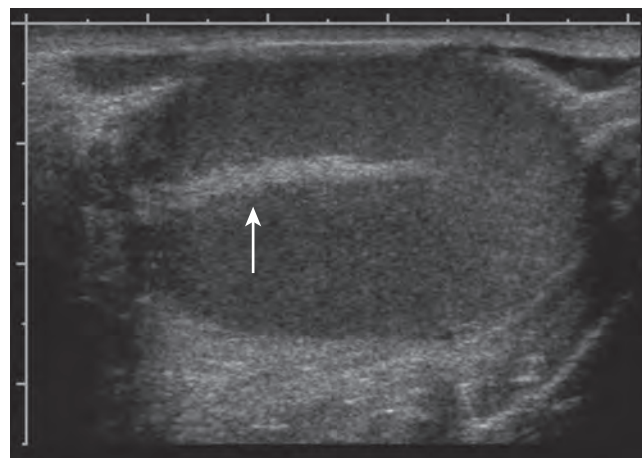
Testis ultrasound image demonstrating rete testis (arrow).
